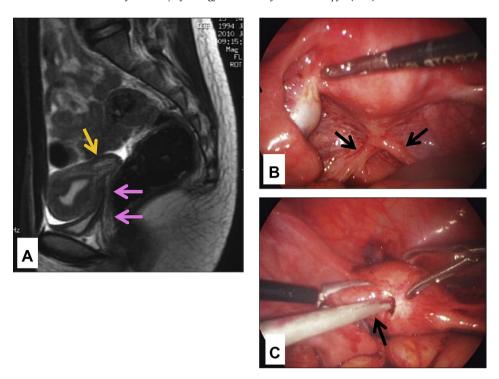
Imaging findings of the genital organs. Magnetic resonance imaging (MRI) findings, sagittal section. (A) The uterine cervix is small (yellow arrow) and the vagina is unobservable (pink arrows). (B) The body of the uterus and bilateral adnexa were normal, but the uterine cervix was thin and short, so bilateral uterosacral ligaments approached toward the midline (black arrows). (C) The uterus was opened at the fundus using a monopolar needle and an Endo Onion was inserted (black arrow) and strongly pushed inferiorly to reveal the uterine cervix.
